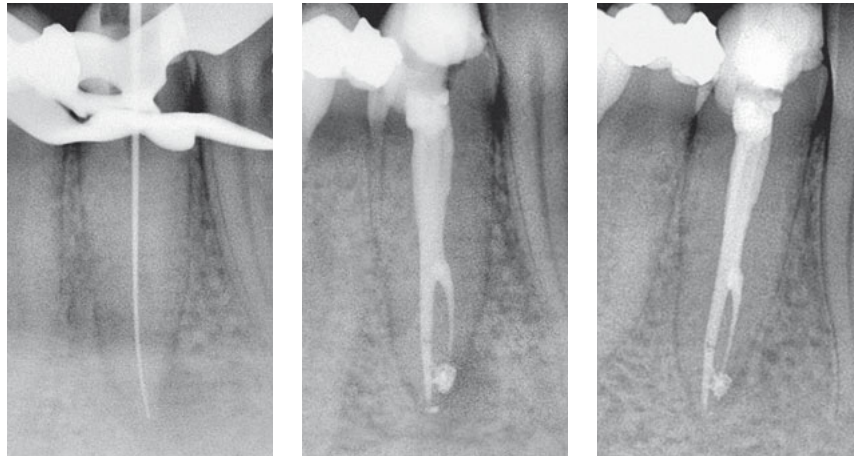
Following copious irrigation and passive ultrasonic activation of the irrigant (sodium hypochlorite), the branched canal was obturated using a thermoplastic obturation technique (courtesy of Dr Thomas Beyl – Lahnstein).
